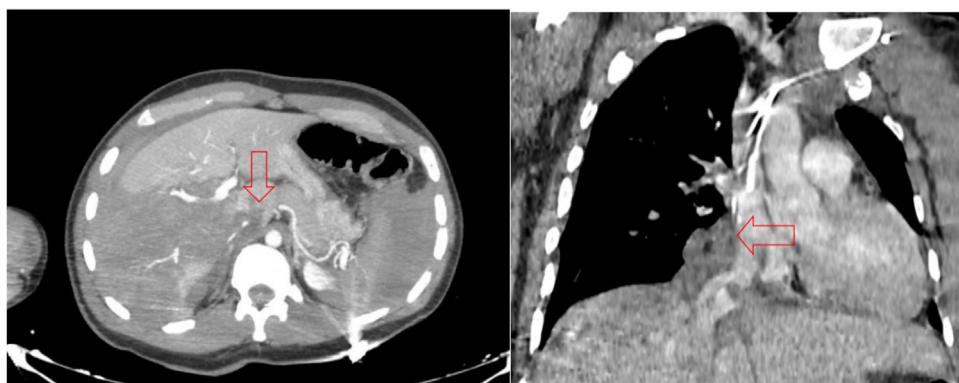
Abdomen CT scan showing rupture of the IVC (red arrow) with hepatic laceration.
